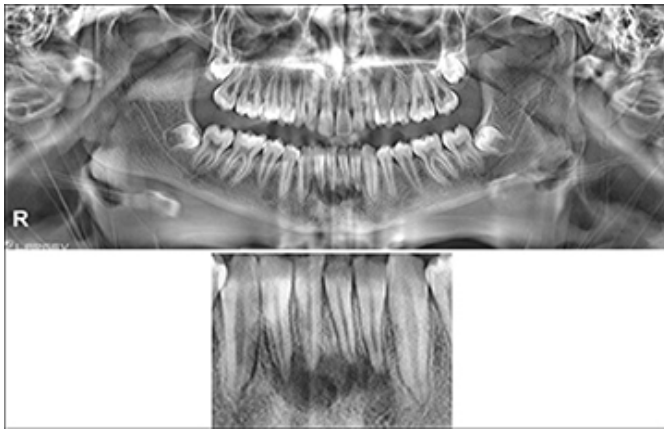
Panoramic radiograph revealing an irregular radiolucency (2 x 2 cm) surrounding the roots of lower central and lateral incisors.
